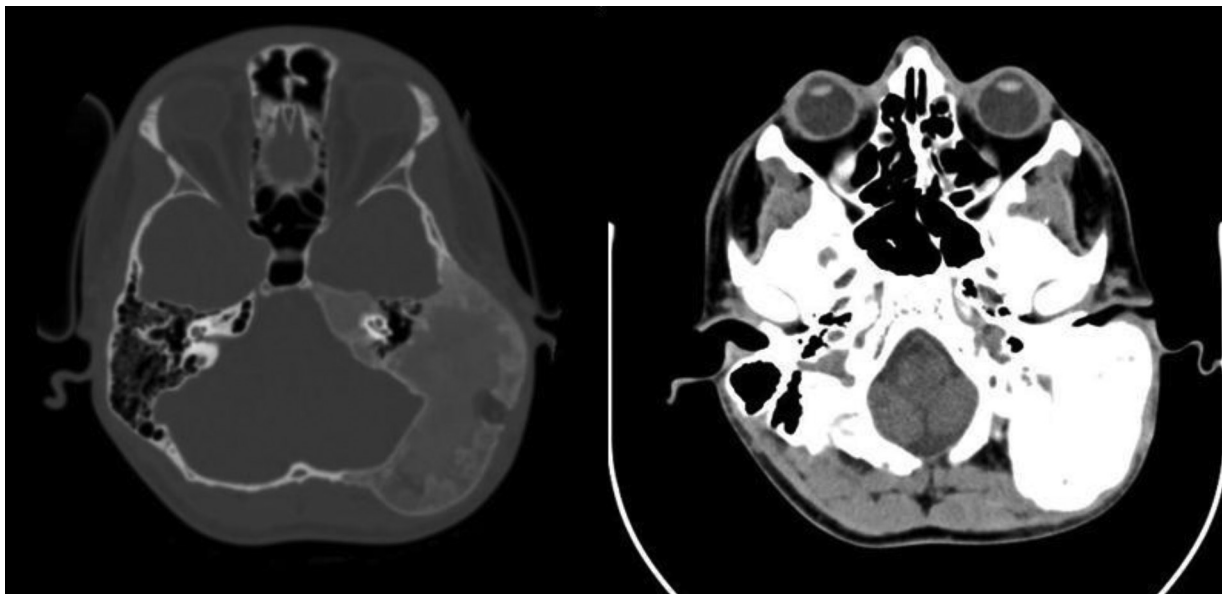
CT axial images demonstrate fibrous dysplasia involment of the left cranial base. The pathognomonic appearance is the homogenous “ground-glass”, increased density of involved bones
